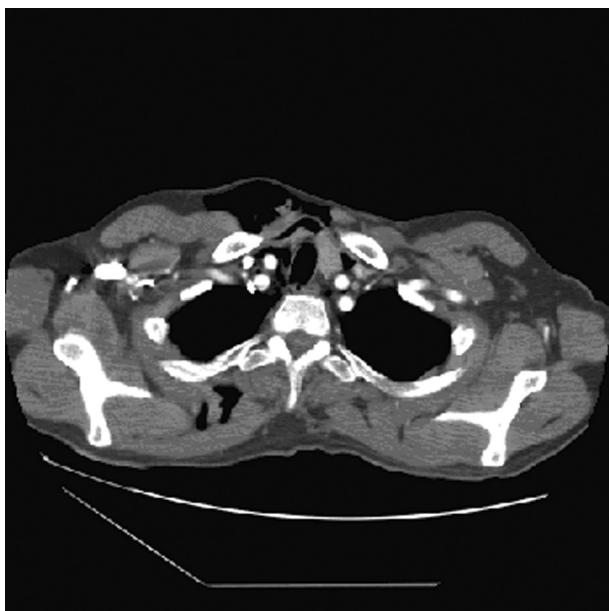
CT showing subcutaneous emphysema.
